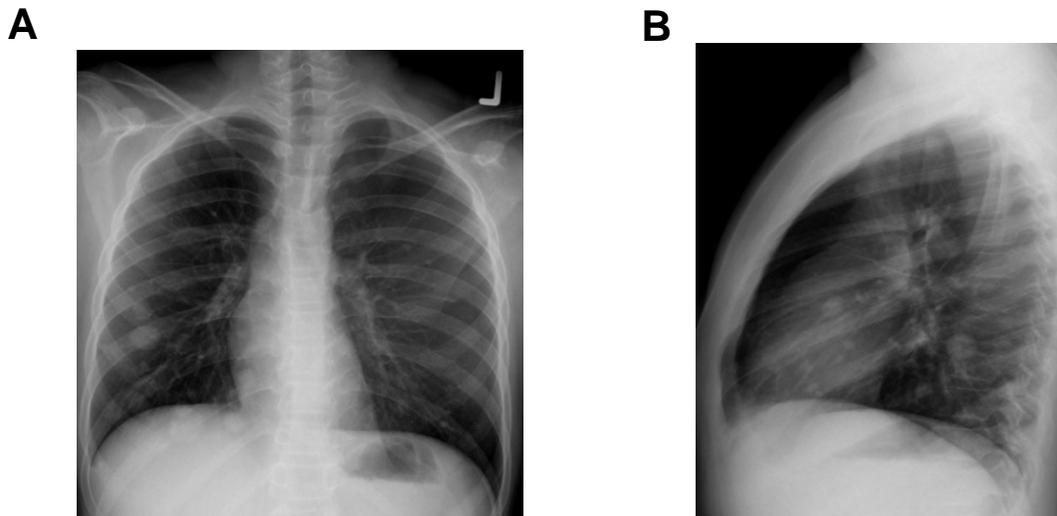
Chest radiograph of a 14-year-old girl with osteosarcoma at the right tibia. (A) PA image showing pneumothorax at the left hemithorax; (B) Lateral image did not show this abnormality.
